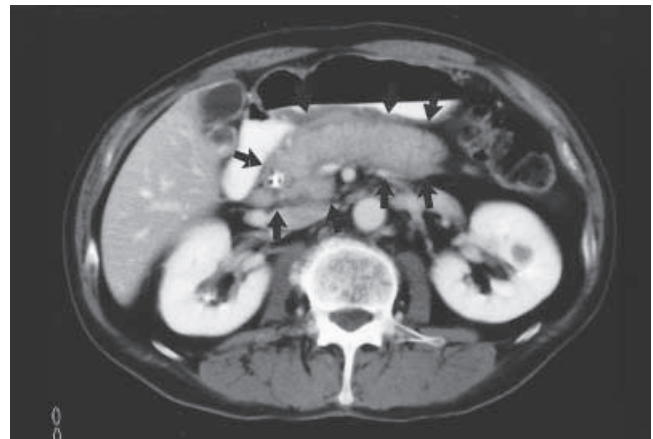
Follow-up CT shows diffuse swelling of the entire pancreas, with a capsule-like rim (arrows)
